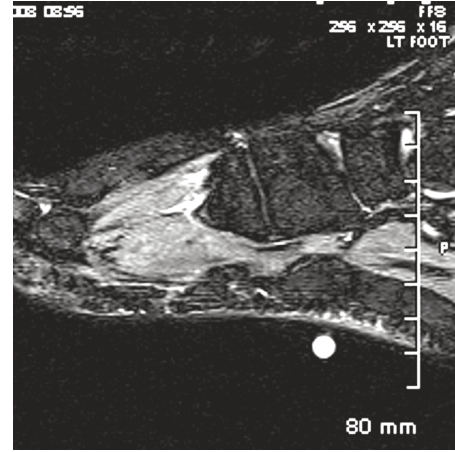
T2-weighted image of the same lipoma shown in Figure 9, demonstrating the isointensity of the mass to the surrounding fat.
